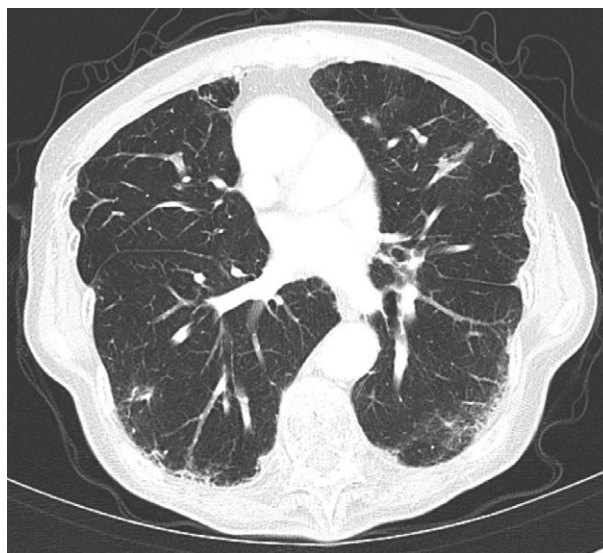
Multiple pulmonary metastases in a 75-year-old female patient with bladder cancer. Initial chest computed tomography shows multiple pulmonary metastases.
